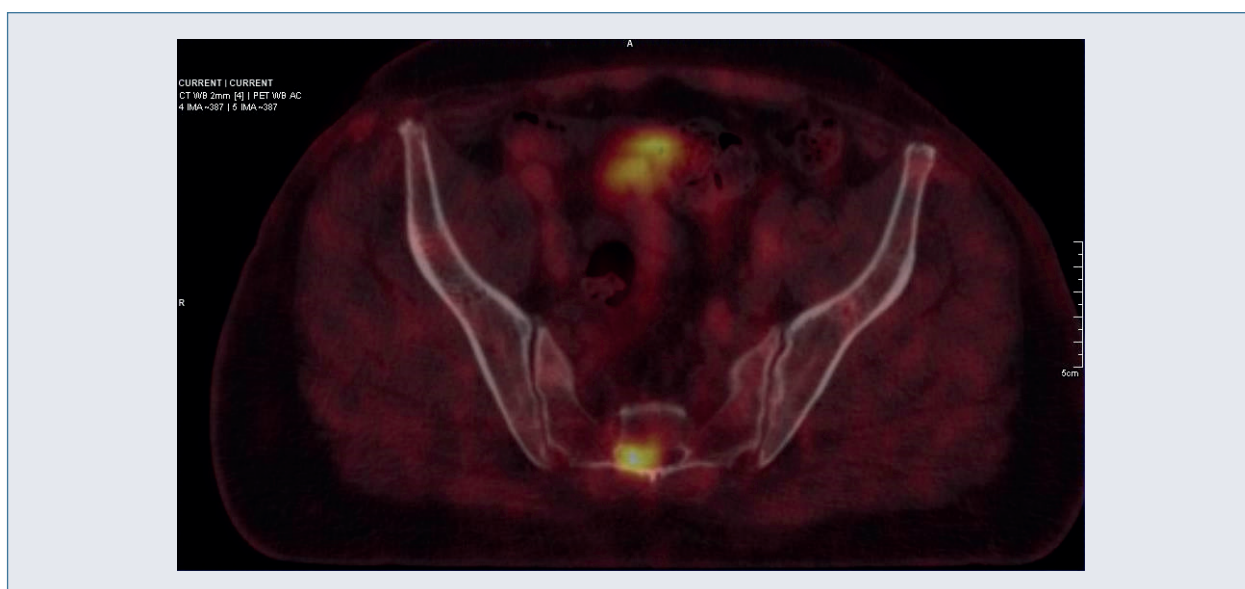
Positron emission tomography-computed tomography scan of pelvis
